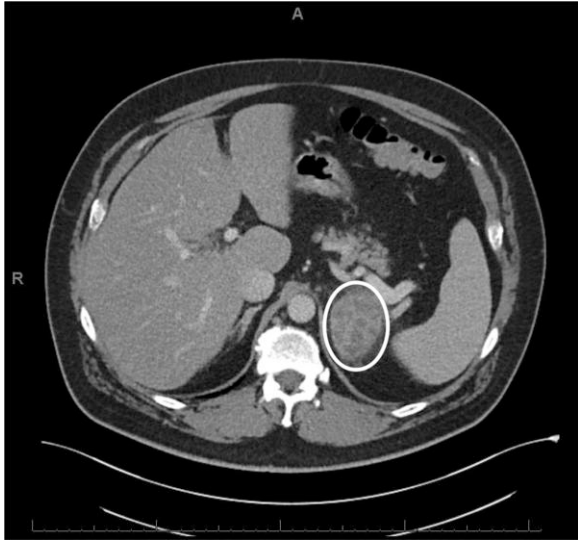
Abdominal computed tomographic scan highlighting a 9×4.2-cm heterogeneous left adrenal mass (circled in white).
